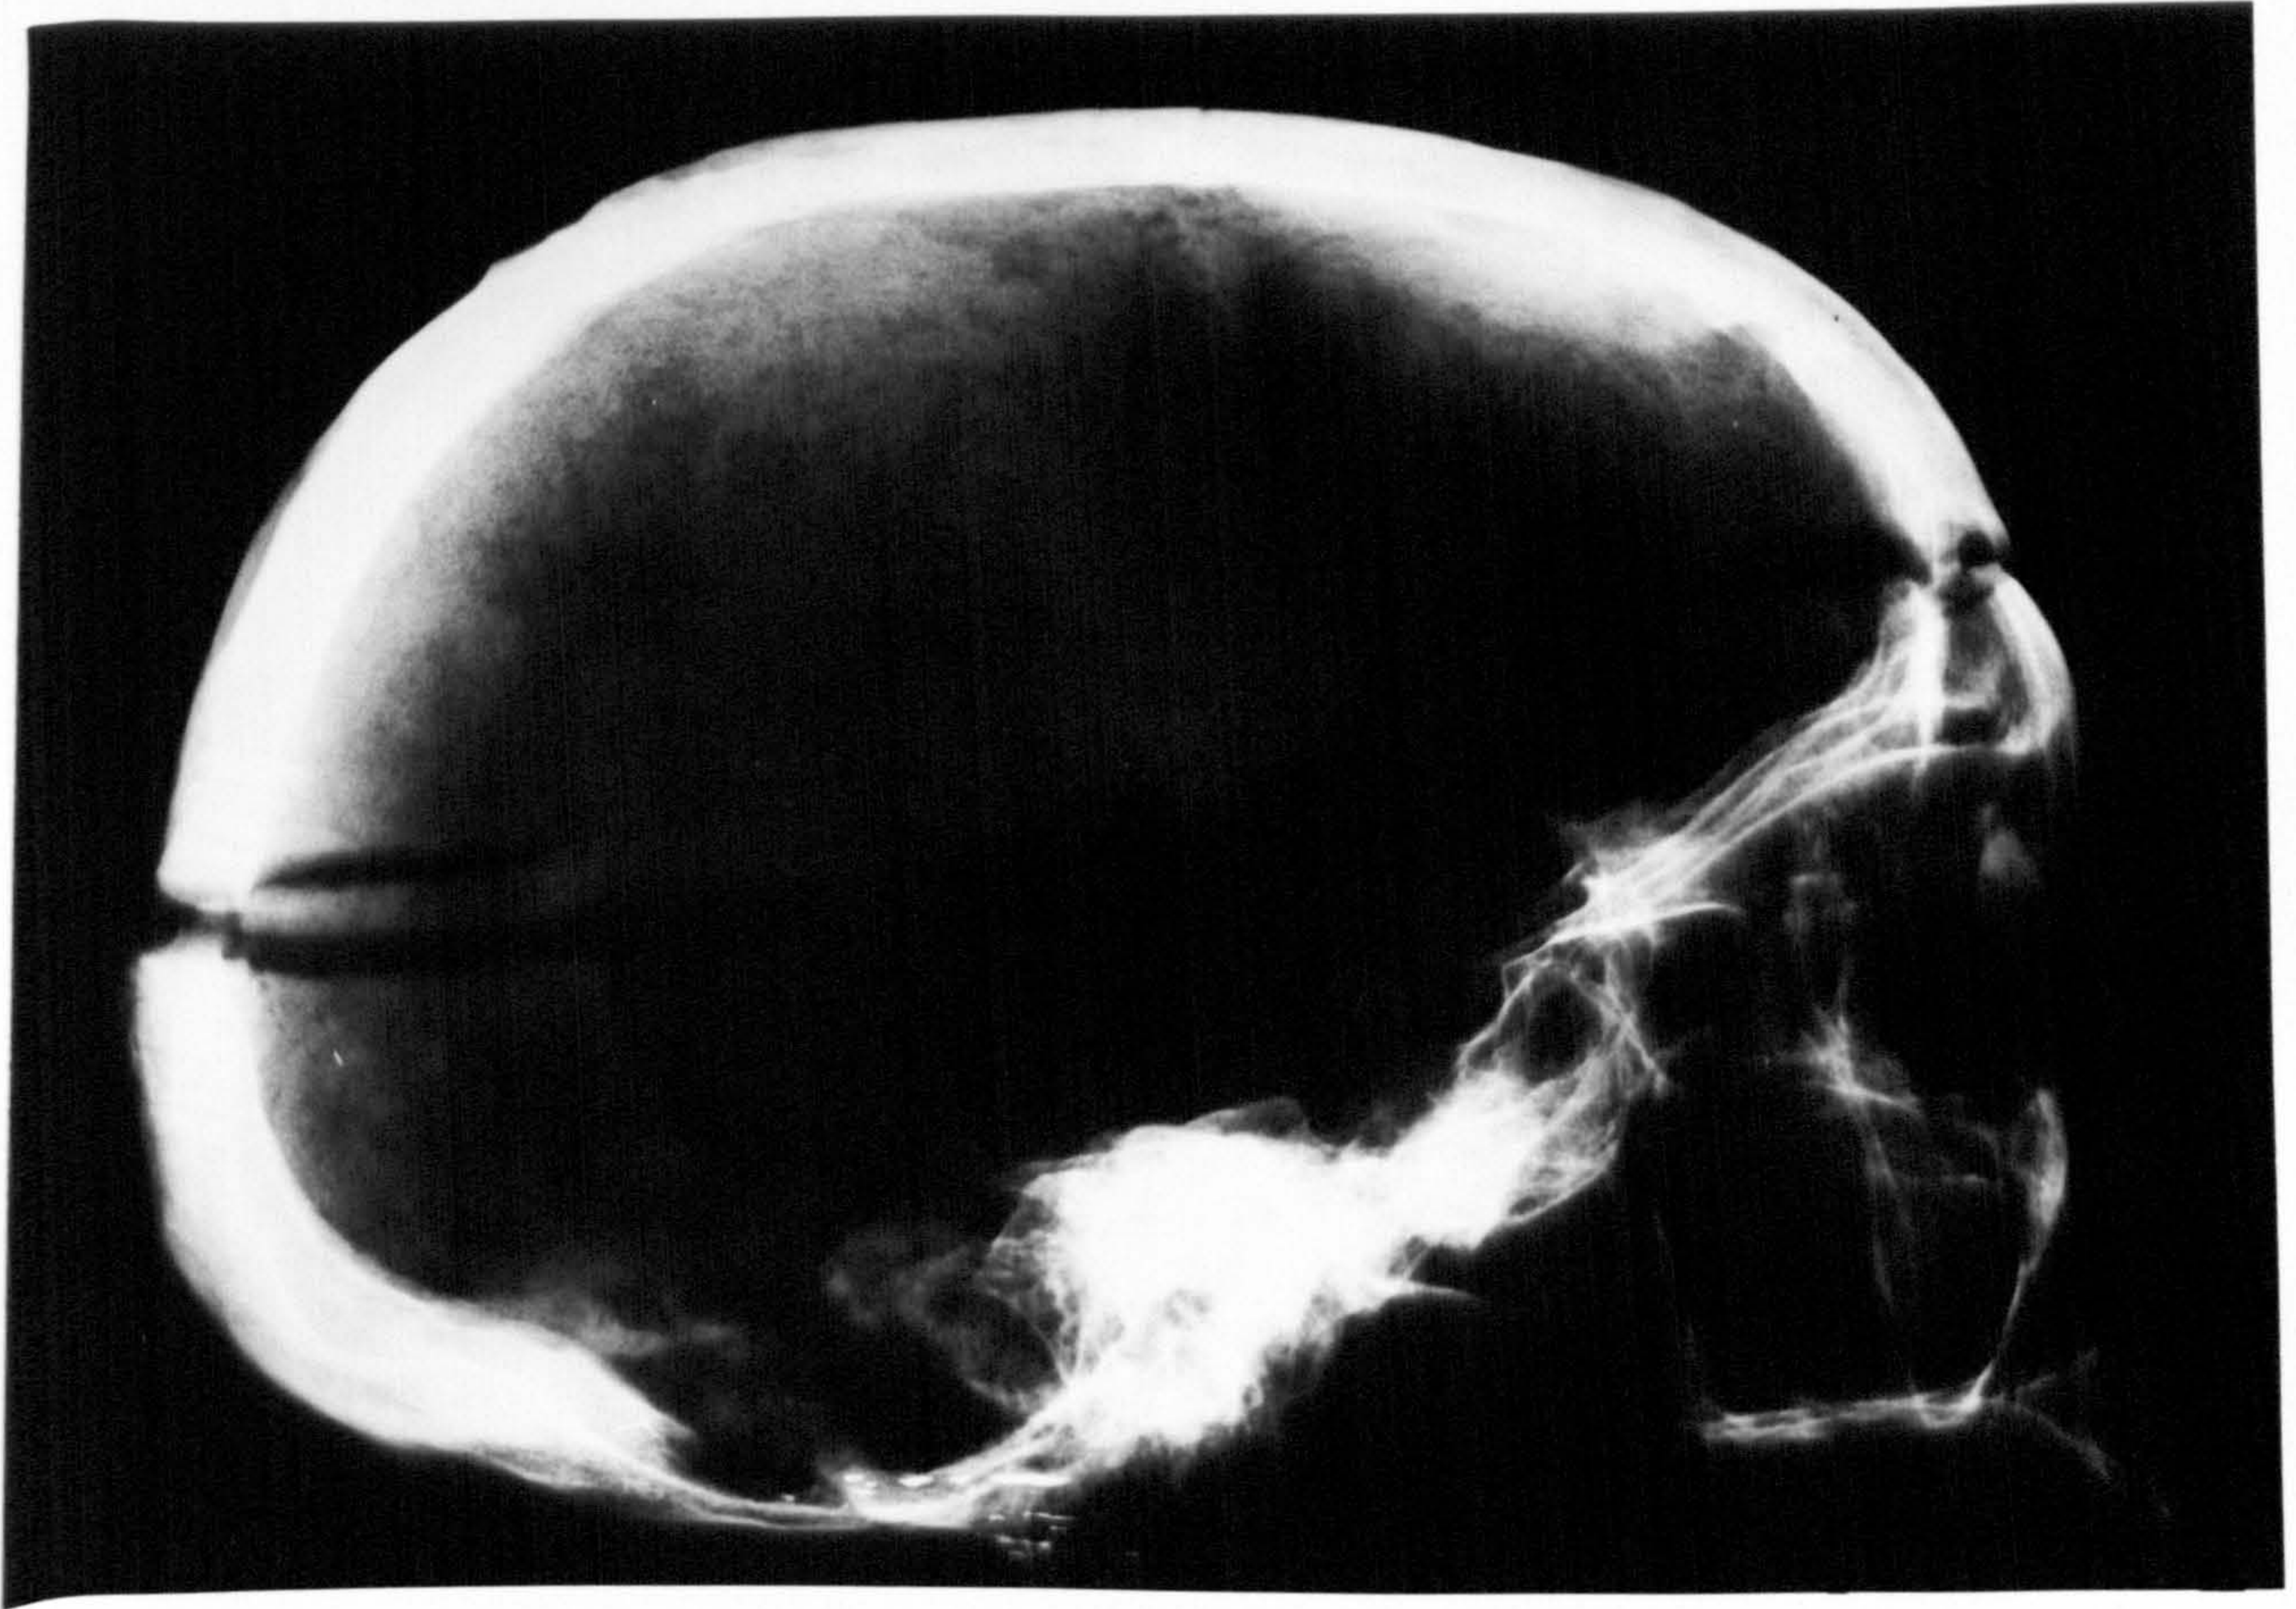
X-ray appearance and visual appearance of grade 2 HFI
